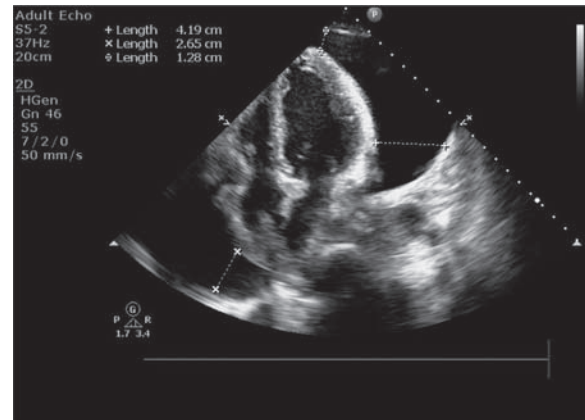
Urgent echocardiogram showed a very large pericardial effusion with typical features of tamponade. Patient had similar echocardiographic features 5 times within a span of 30–40 days necessitating urgent pericardiocentesis.
